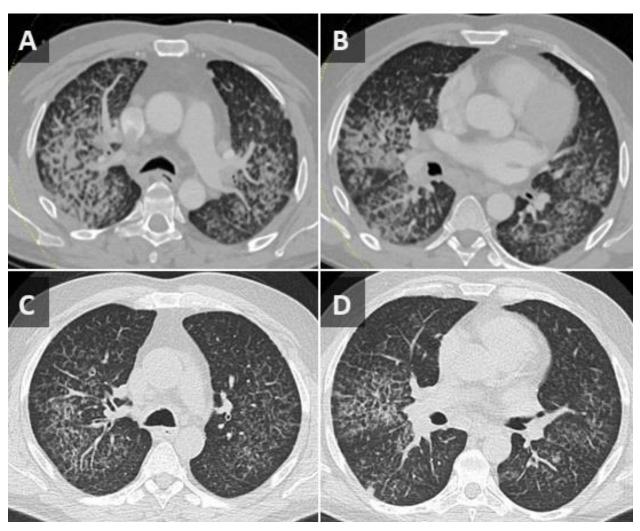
Axial CT images from a contrast-enhanced chest CT performed on the patient at time of admission (A,B) demonstrate a combination of smooth septal line thickening and superimposed ground glass, resulting in a "crazy paving" appearance. A noncontrast chest CT performed at an outside hospital 2 months earlier also demonstrates "crazy paving"; however, the findings have progressed significantly during the 2 intervening months.
